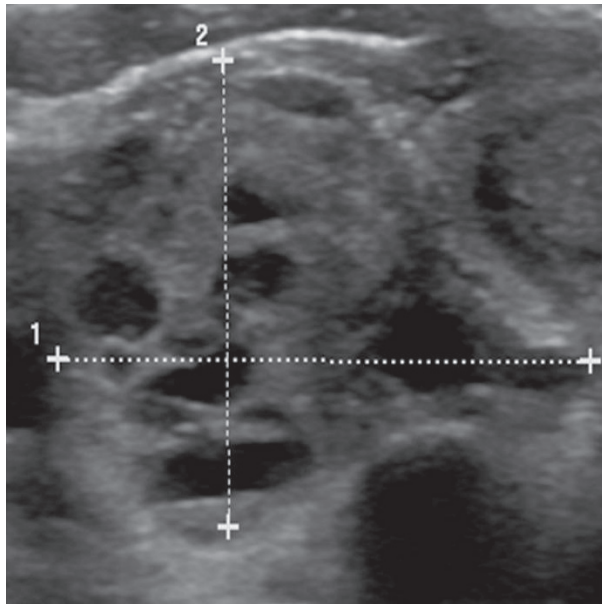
Neck ultrasonography image nine months after the treatment. The maximum dimension of the mass is 3.0cm---slightly smaller.
